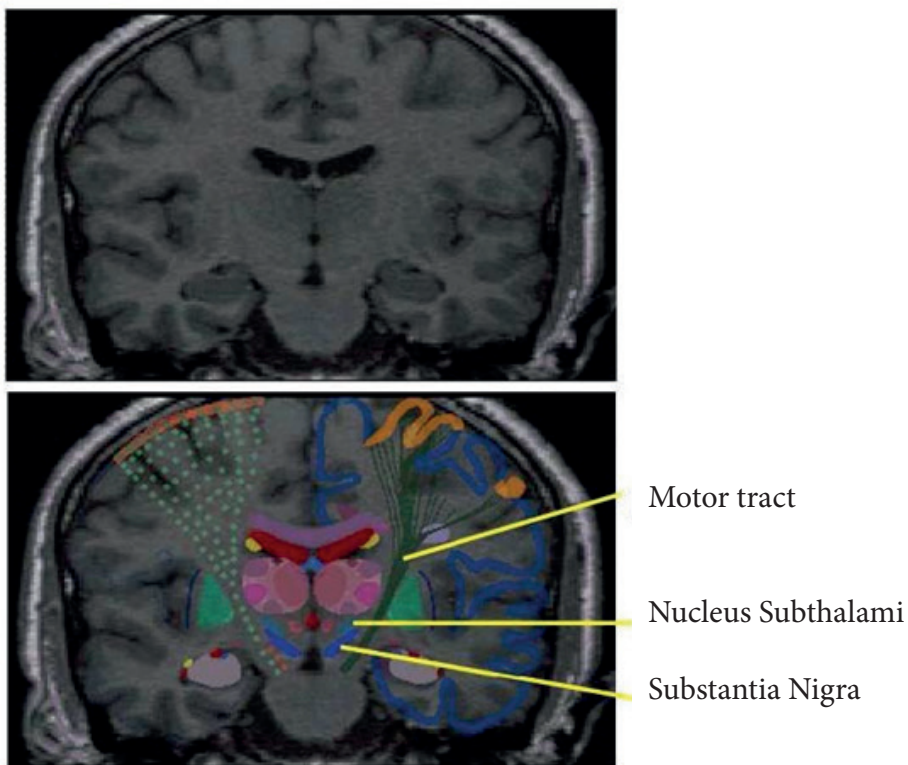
warping a neuro-anatomy atlas on 3D MRI data⁵¹
